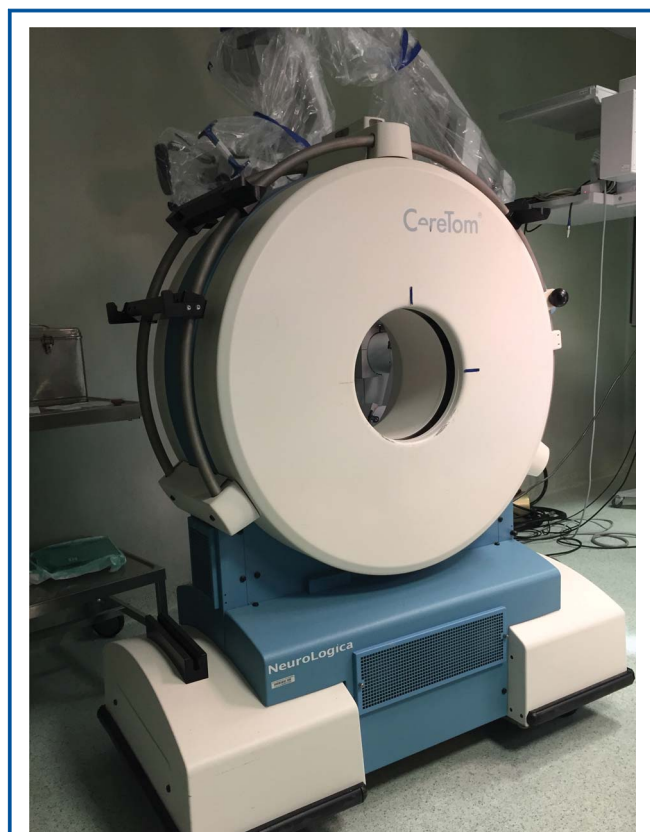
The 8-slice, small-bore portable computed tomography scanner (CereTom NeuroLogica) used both intraoperatively and on the ward at our institution.
